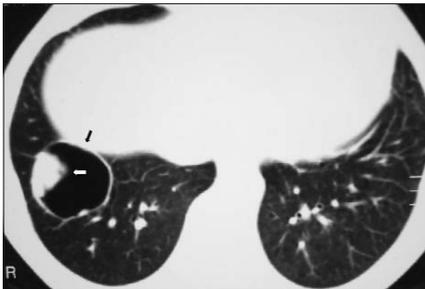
Computed tomography image showing the aspergilloma (black arrow) containing fungal debris (white arrow) on lung window image
